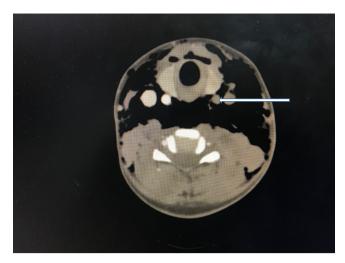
Axial section CTA showing non-opacification of left CCA.
